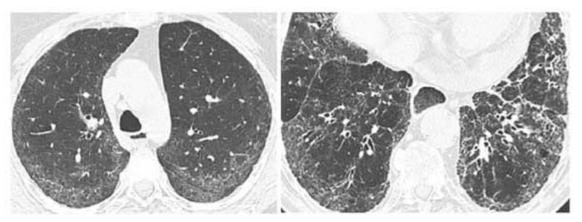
HRCT in a Systemic Sclerosis patient shows reticular and ground glass abnormalities predominantly at the lung bases.
